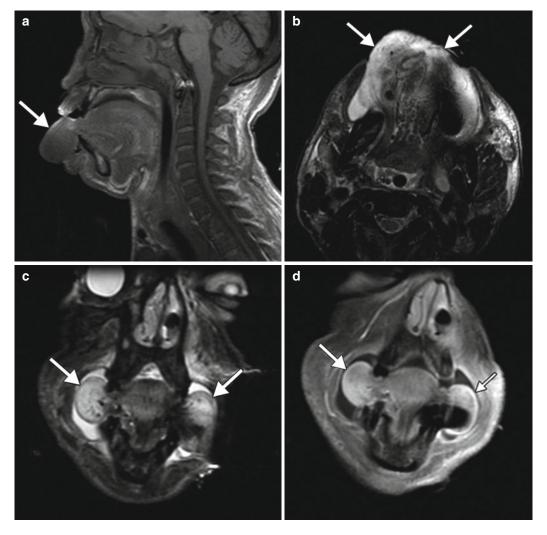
Focal ACE inhibitor angioedema. Sagittal T1-weighted (a), axial (b) and coronal T2-weighted (c), and coronal post-contrast T1-weighted (d) MR images show diffusely massive tongue edema (*arrows*)
